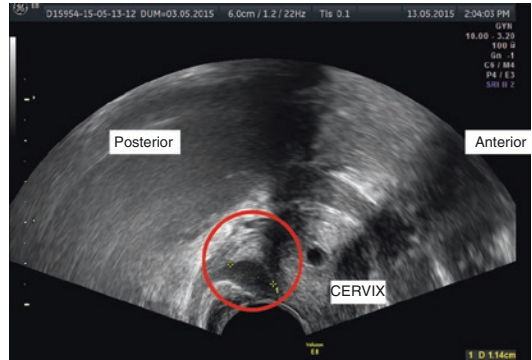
A cystic forniceal nodule as visualized using transvaginal ultrasonography
